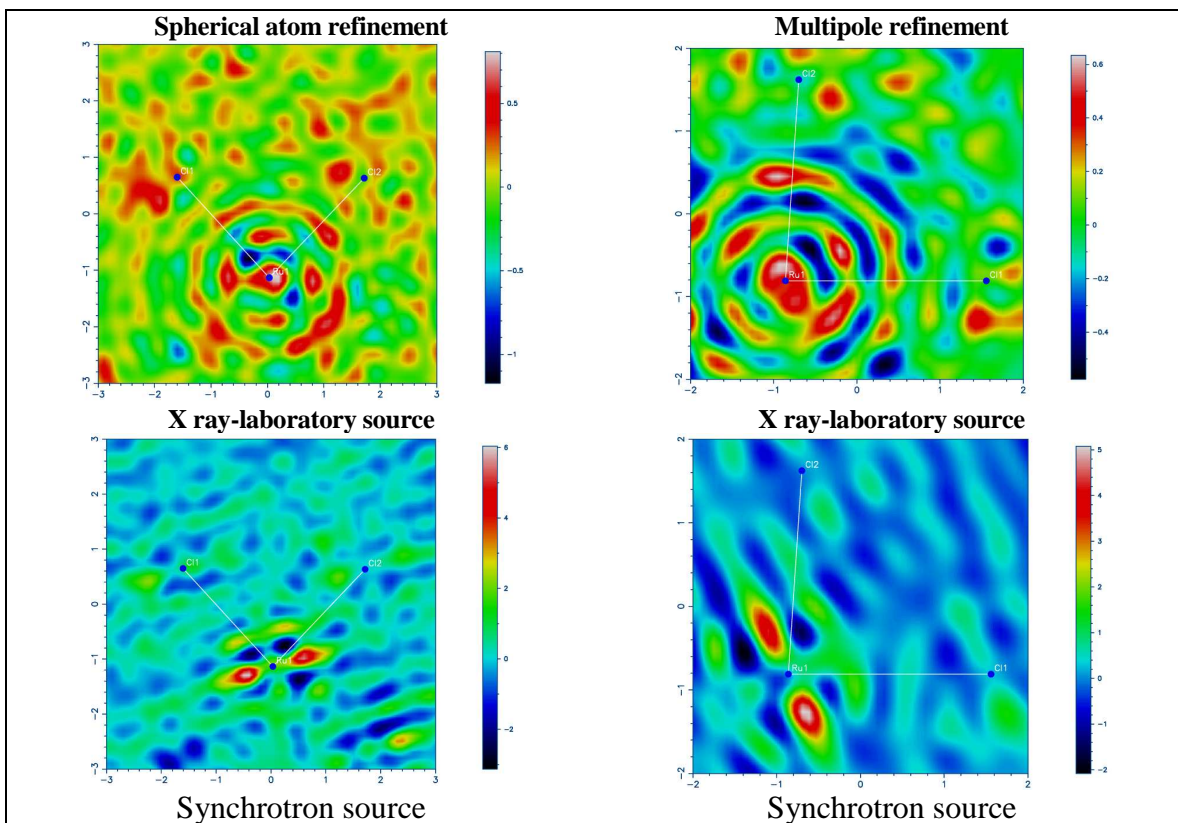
Residual Fourier density maps of form IV from synchrotron and X-ray laboratory sources for spherical and multipole refinements.
